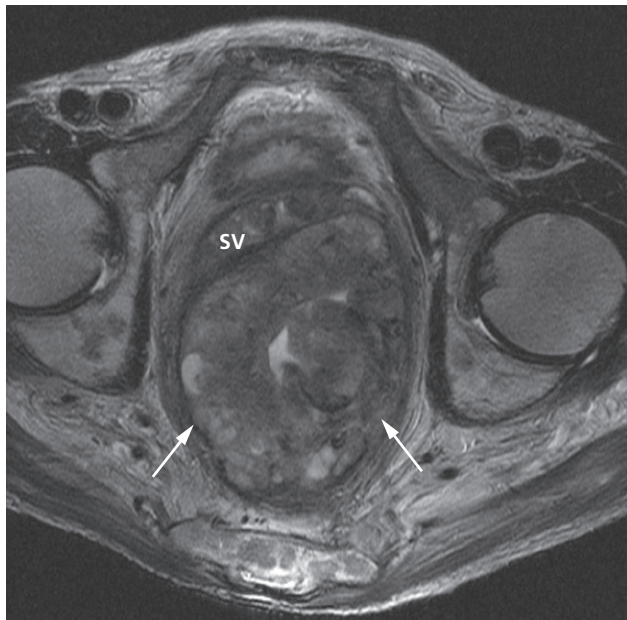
MRI of advanced rectal carcinoma. The tumour (arrows) has completely invaded the perirectal fat and fascia and there is infiltration of the seminal vesicles (SV).
